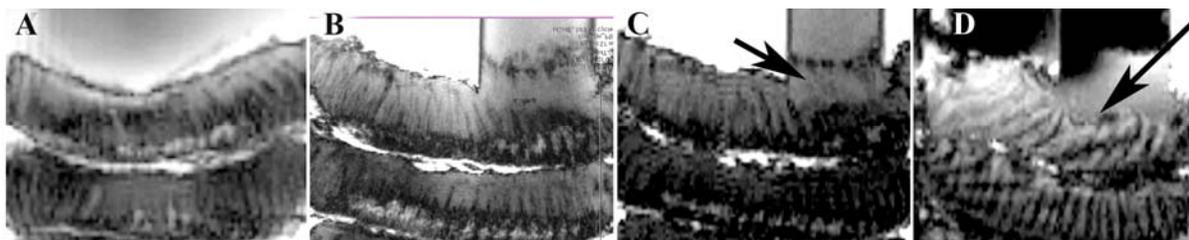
The skin microimaging at 21 Tesla MRI using fast 3D FLASH technique shows control without carbon nanotubes (A); carbon nanotube sample in tube placed for 3 minutes on skin top (B); after 15 minutes carbon nanotube sample in tube placed on skin top (C); after 6 hours carbon nanotube sample stayed on top of the skin (D). Notice the slow damage to epidermis and dermis by carbon nanotubes caused shown by arrow.
